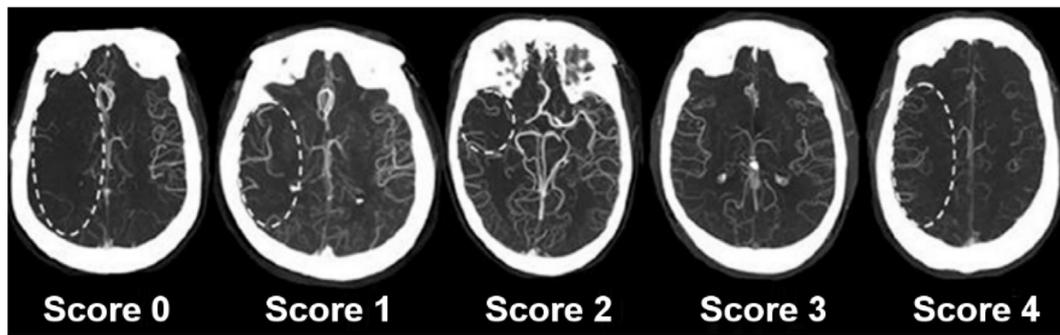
Collateral Score System: 0 = absent collaterals > 50% of an M2 territory; 1 = diminished collaterals > 50% M2 territory; 2 = diminished collaterals < 50% M2 territory; 3 = Collaterals equal to contralateral side; and 4 = increased collaterals. CS of 0 has been validated as a predictor of large infarct core with DWI MRI at presentation and poor outcome independent of successful recanalization. (Image reproduced with permission from Souza et al. [9].)
